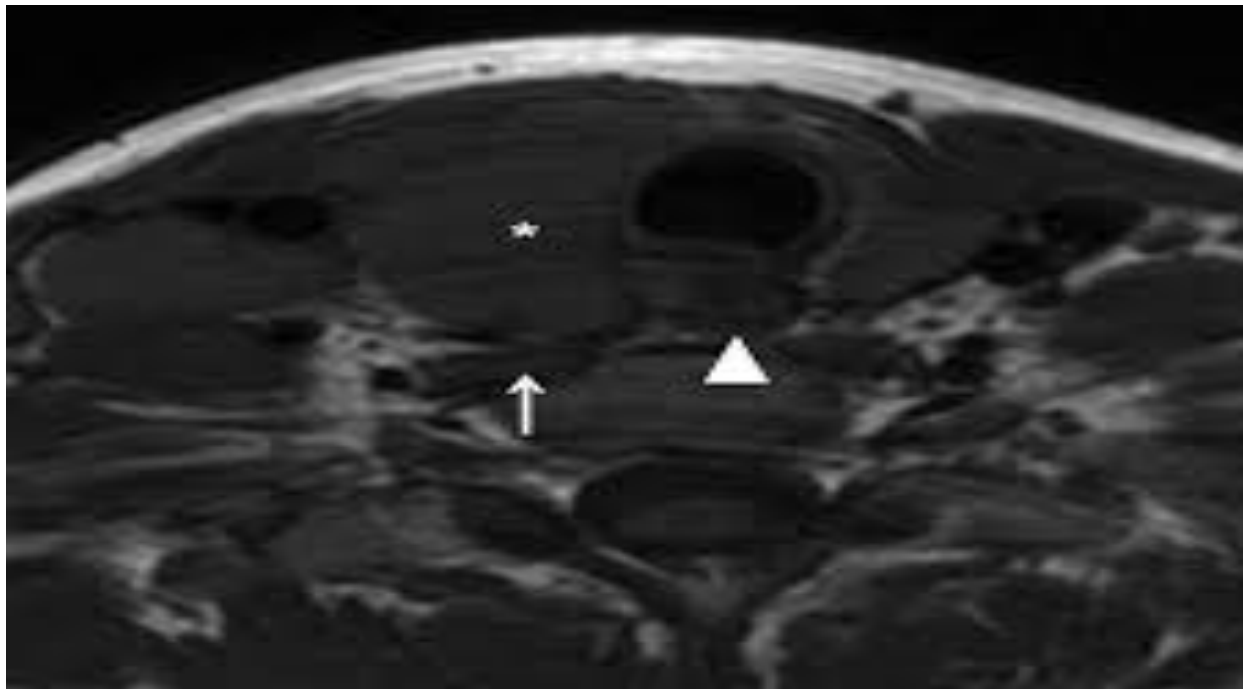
Neck MRI demonstrating bilateral cervical lymph node involvement without deep tissue or mediastinal extension.
